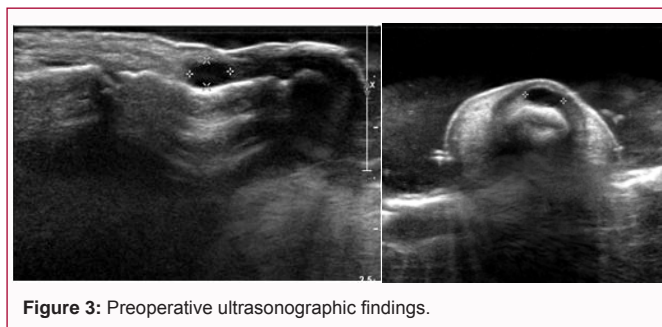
Preoperative ultrasonographic findings.
